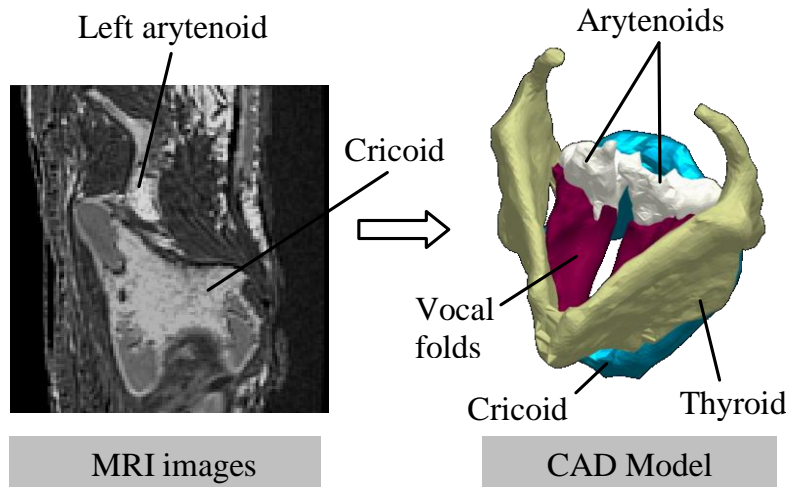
MRI-based synthetic larynx model fabrication process
